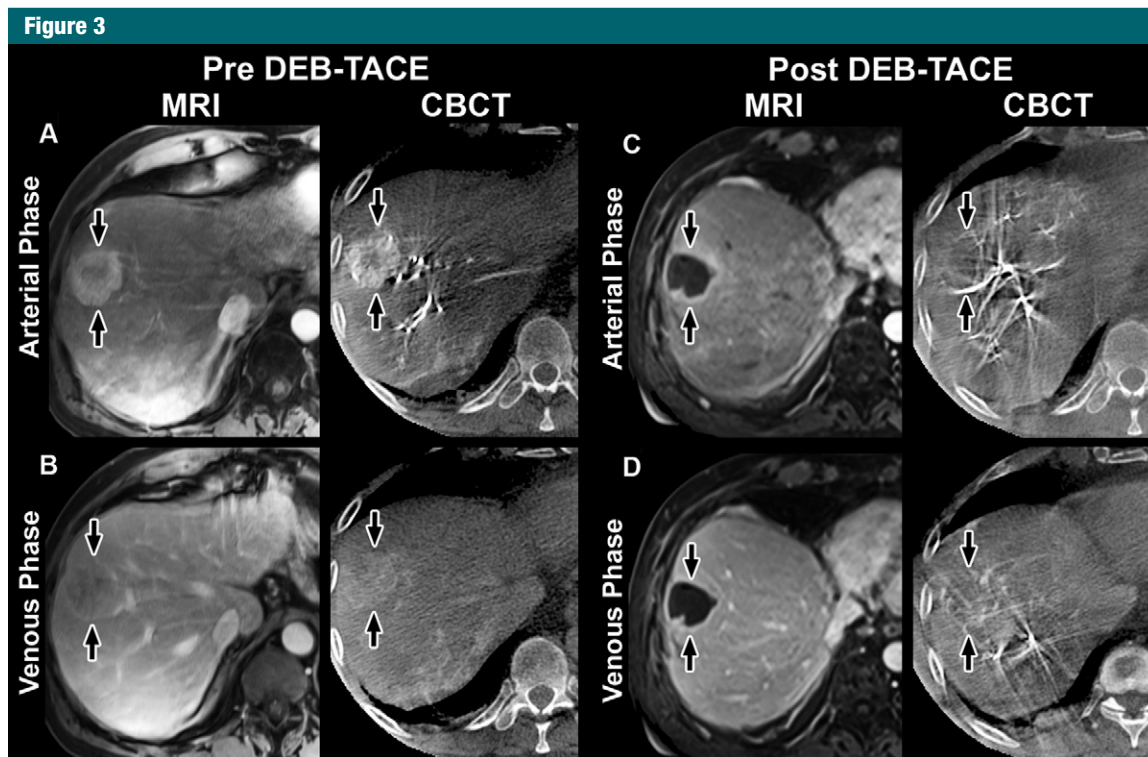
Representative T1-weighted axial contrast-enhanced arterial and portal venous phase MR images (*MRI*) and axial contrast-enhanced early or arterial phase and delayed or venous phase cone-beam CT scans (*CBCT*) in 73-year-old man with cryptogenic HCC in right lobe. MR images were acquired approximately 1 month before and 1 month after TACE with doxorubicin-eluting beads (*DEB*), whereas dual-phase cone-beam CT scans were acquired intraoperatively before and immediately after delivery of doxorubicin-eluting beads during TACE. *A*, Arterial phase images obtained before TACE. MR image shows a 75-mm mass in right lobe with 65% enhancement. Mass has similar enhancement (75%) on cone-beam CT scan. *B*, Venous phase images obtained before TACE. MR image shows mass with 60% enhancement. Similar enhancement (70%) is seen on cone-beam CT scan. *C*, Arterial phase images obtained after TACE. Mass shows almost no enhancement (5%) on MR image, and tumor has decreased to 69 mm. On cone-beam CT scan, intraprocedural mass enhancement decreased by 87%, which allowed prediction of an objective EASL response at 1 month. *D*, Venous phase images obtained after TACE. Mass shows no enhancement (0%) on MR image. Intraoperative enhancement decreased by 93% on cone-beam CT scan, enabling prediction of an objective EASL response at 1 month. As shown here, the patient has shifted in position between acquisition of the post-TACE MR images and the cone-beam CT images and pre-TACE MR images, which explains some differences in tumor size and morphology despite the fact that images were obtained at same level.
